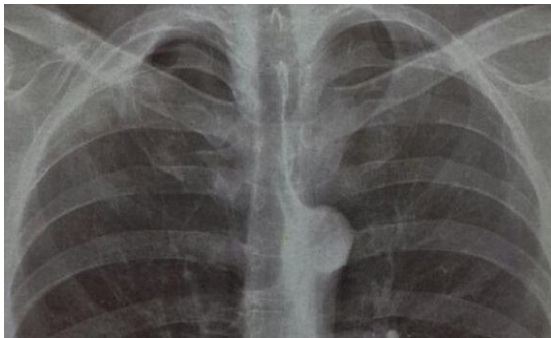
The upper half of AP view chest X-ray. There is a small homogenous shadow in the apical region of the right lung.
